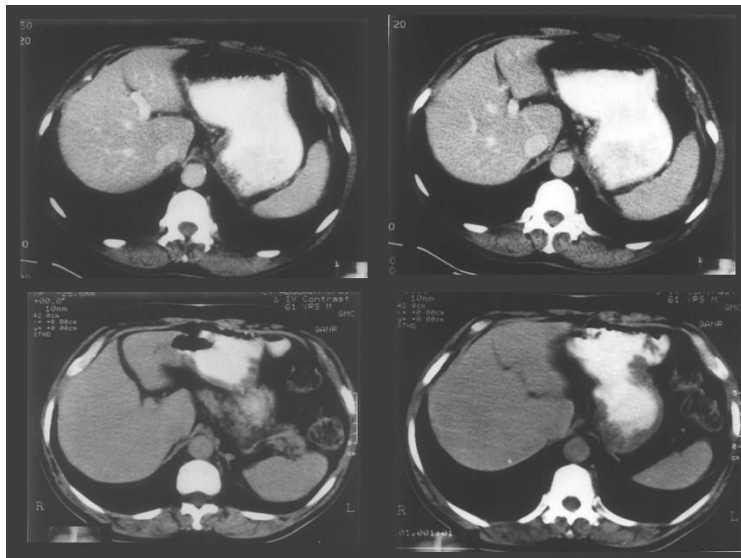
Abdominal CT Scan of the patients at presentation.
